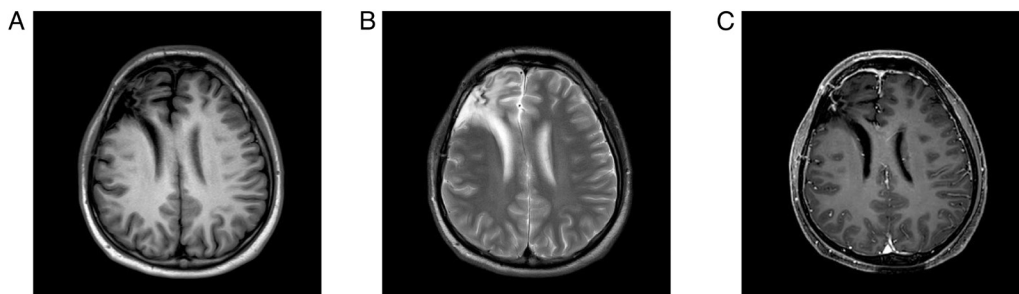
Follow-up magnetic resonance imaging at 3 months postoperatively. (A) T1-weighted image showing an irregularly shaped surgical cavity in the right frontal region with hypointense signal; discontinuity of the right frontal bone is noted, compatible with a postoperative change/bone defect. (B) T2-weighted image showing a hyperintense signal within the surgical cavity and patchy edema in the adjacent right frontal lobe parenchyma. (C) Contrast-enhanced T1-weighted image showing thickening and enhancement of the cavity margin and adjacent dura mater, with focal nodular enhancement.
